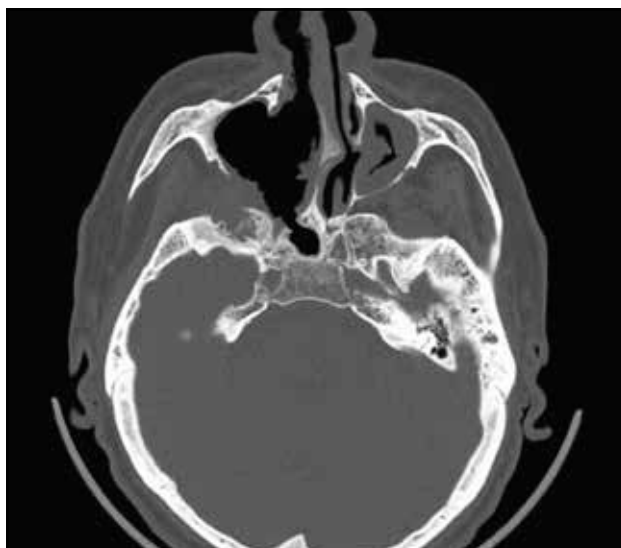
Axial and coronal view of postoperative CT scan – showing complete removal of the medial wall of the maxillary sinus, inferior and middle right turbinate, absence of the medial and inferior part of the lamina papyracea and the vertical plate of the palatine bone and no pathological process.
